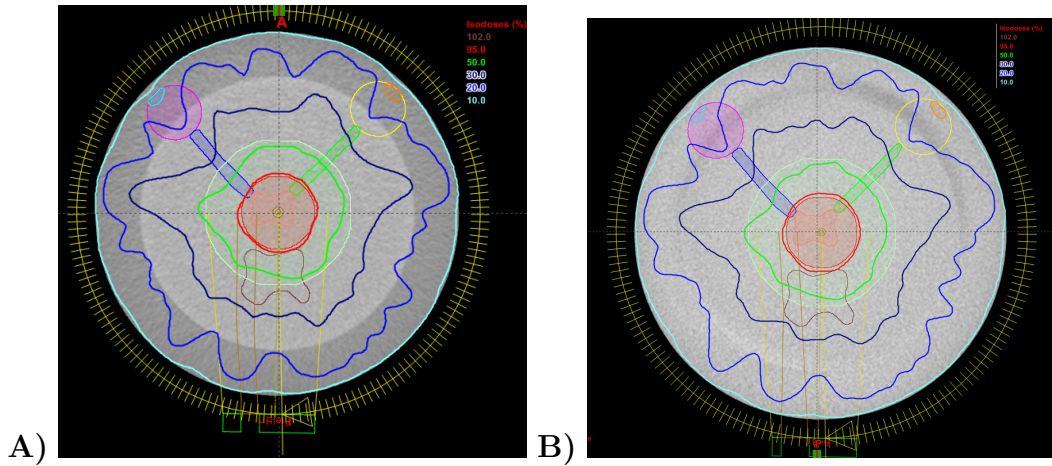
Single VMAT dose distributions on the axial slice with A) CT-based and B) the planning CBCT-based dose calculations.
